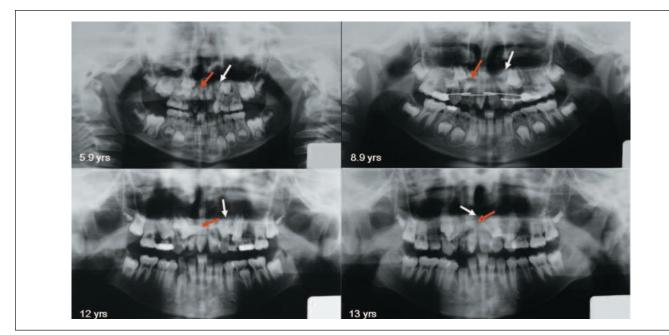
Serial panoramic radiographs showing changes in the eruption direction of the transposed teeth.
